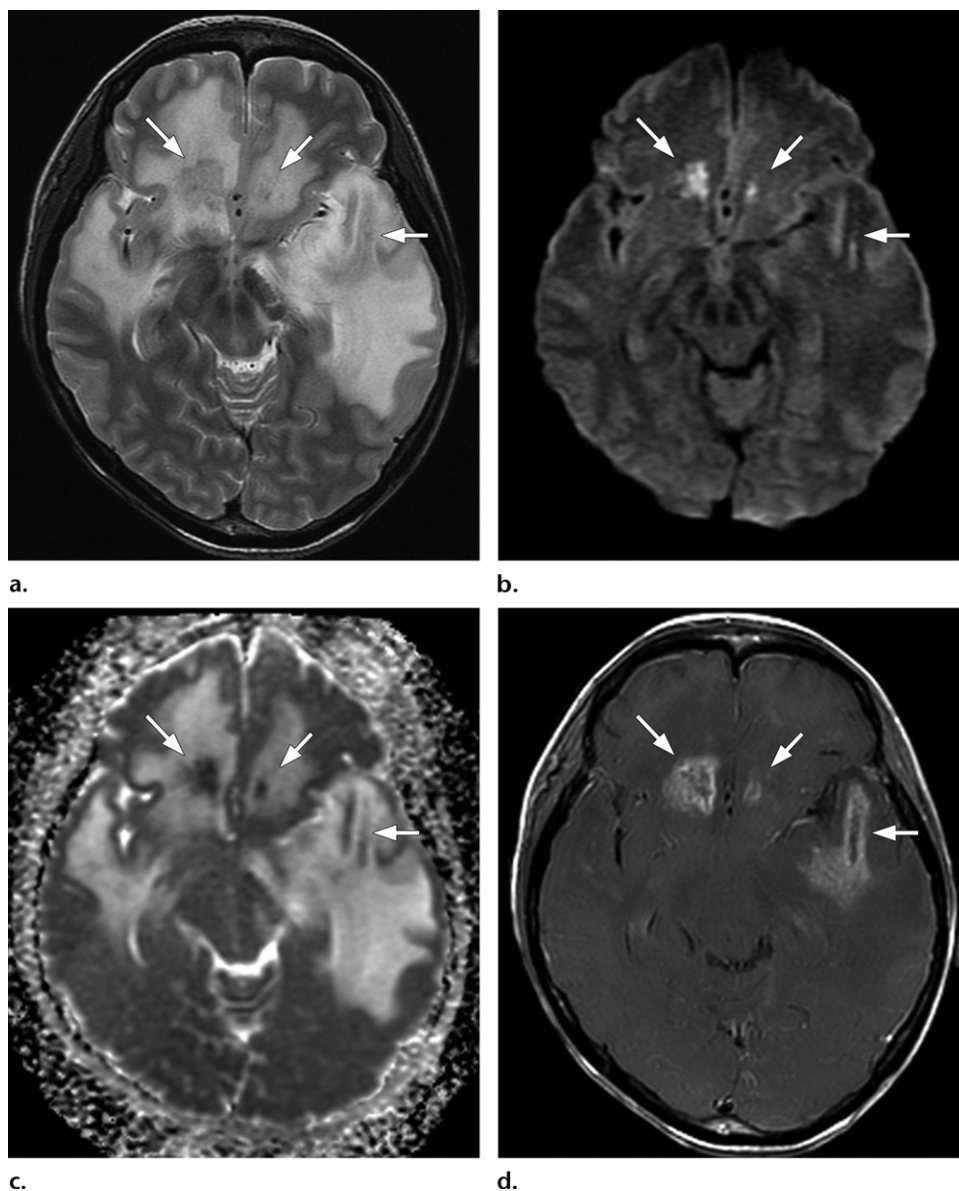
Disseminated necrotizing leukoencephalopathy (DNL) in a 40-year-old woman with primary CNS lymphoma. She presented with changes in behavior, aggression, and memory loss after receiving intrathecal methotrexate and whole-brain RT. (a) Axial T2-weighted image shows extensive white matter hyperintensity involving the bilateral frontal and temporal lobes with multiple low-signal-intensity foci (arrows). (b, c) The T2-hypointense foci are hyperintense on a diffusion-weighted image (arrows in b) and hypointense on an apparent diffusion coefficient (ADC) map (arrows in c), consistent with restricted diffusion. (d) Axial contrast-enhanced T1-weighted image shows that the T2-hypointense foci have ring enhancement (arrows).
